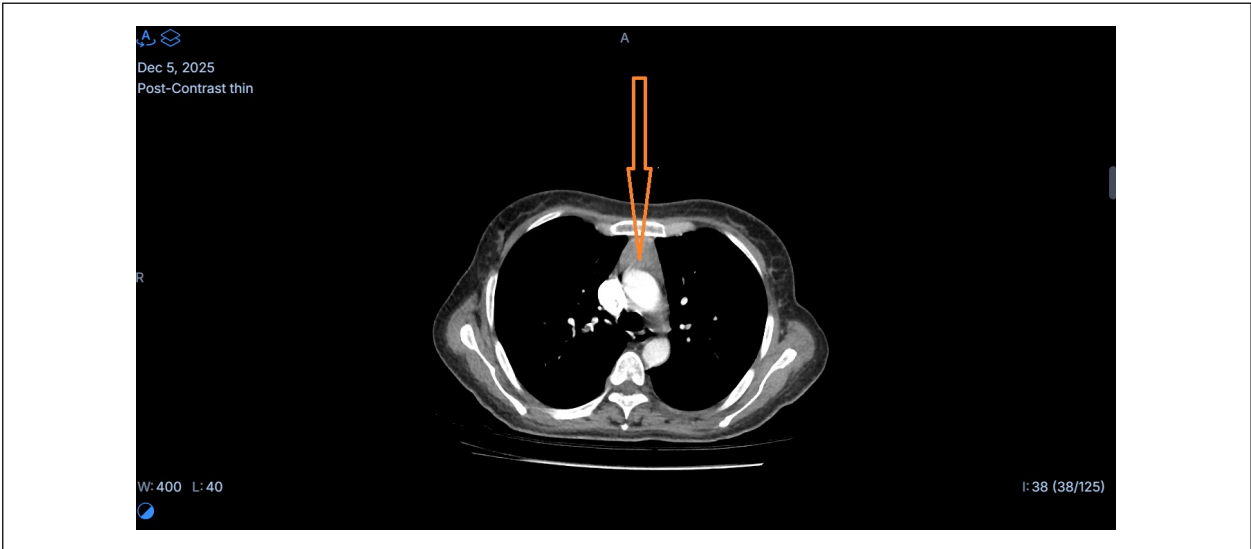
Axial contrast-enhanced CT scan demonstrating thymic enlargement
